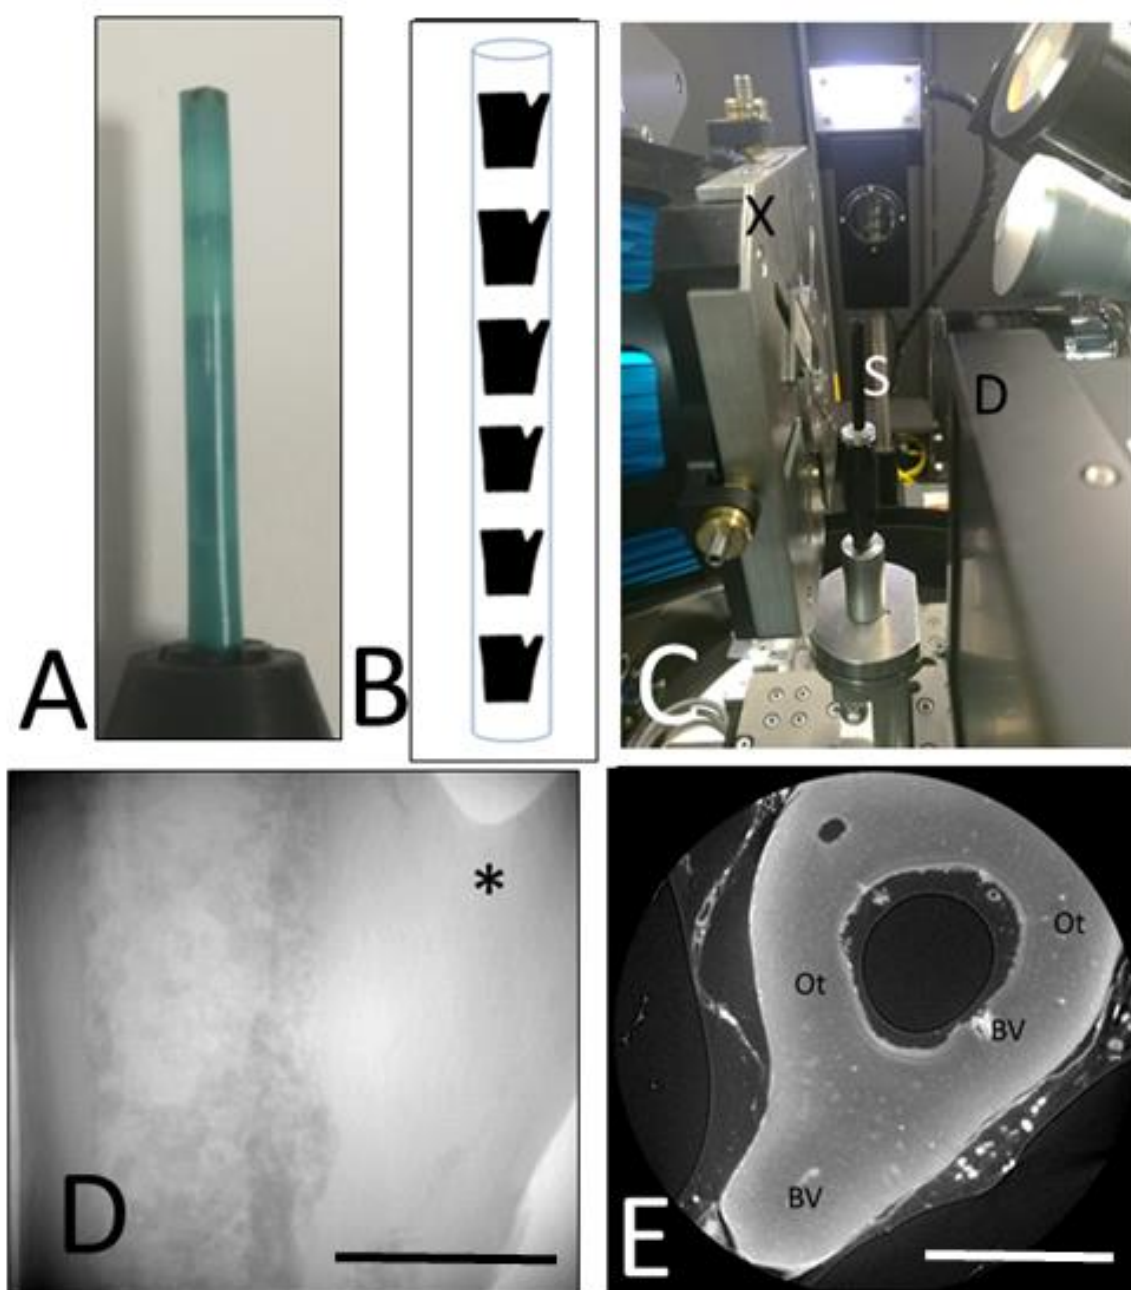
X-ray μ CT imaging.
